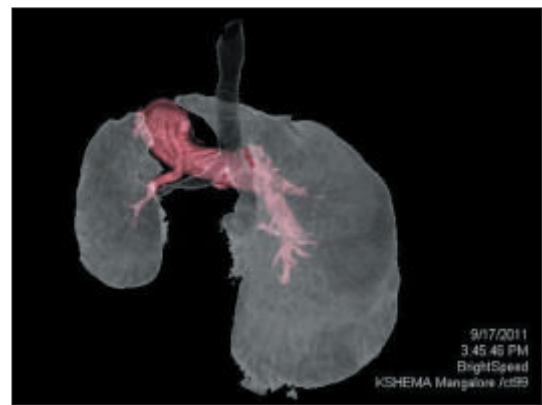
CT thorax VR image
